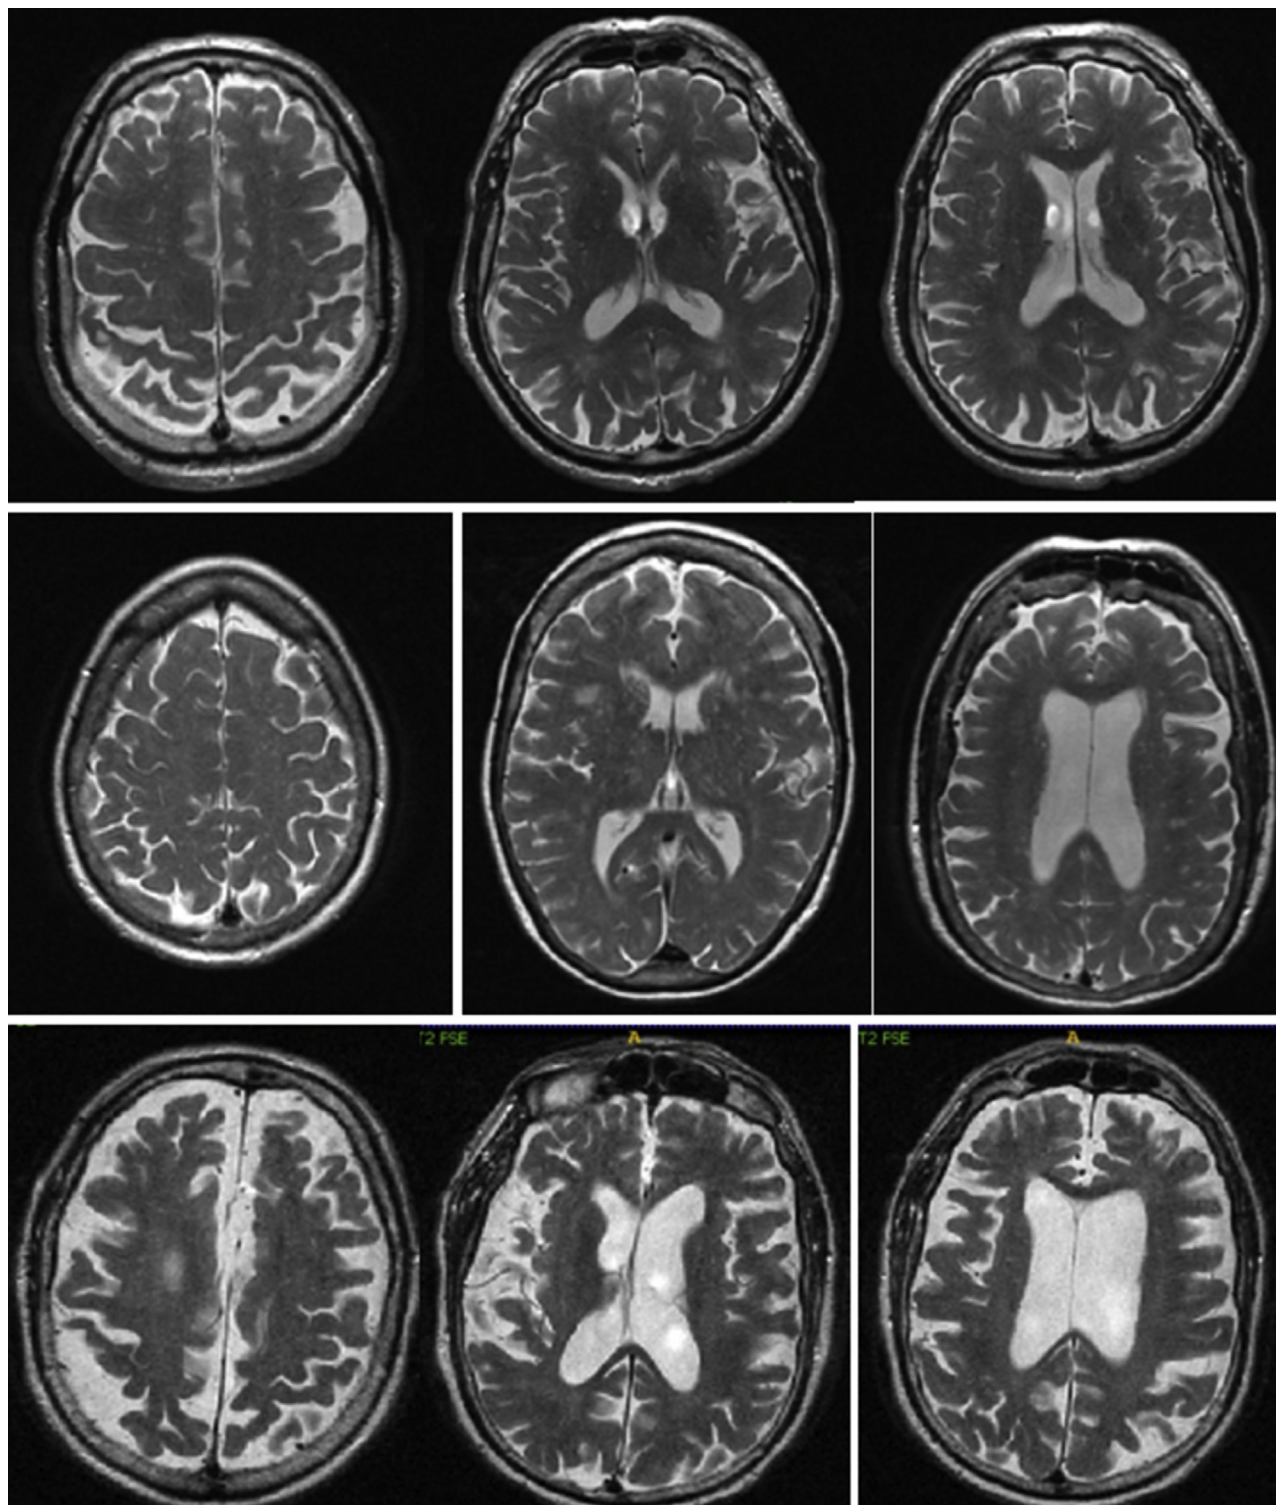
Cross sections from MRI images of CN (the top row), MCI (the middle row), and AD (the bottom row). Abbreviations: MRI, magnetic resonance imaging; CN, cognitively normal; MCI, mild cognitive impairment; AD, Alzheimer's disease.
